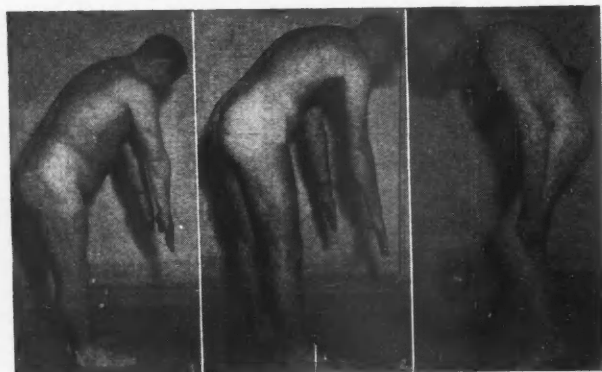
Advanced degree of ankylosis in an apparently healthy male. In the upright position, a normal posture was presented; on flexion, a "poker back". (X-ray findings are shown in Fig. 8.) Fig. 2.—Ankylosing spondylitis, showing flattening of lumbar area with spinal flexion. Fig. 3.—Advanced case of ankylosing spondylitis, the entire spine being completely rigid in the above posture. Note the forward protrusion of the neck and extreme dorsal kyphosis in an untreated case of 30 years' duration. (see x-ray, Fig. 7.)
